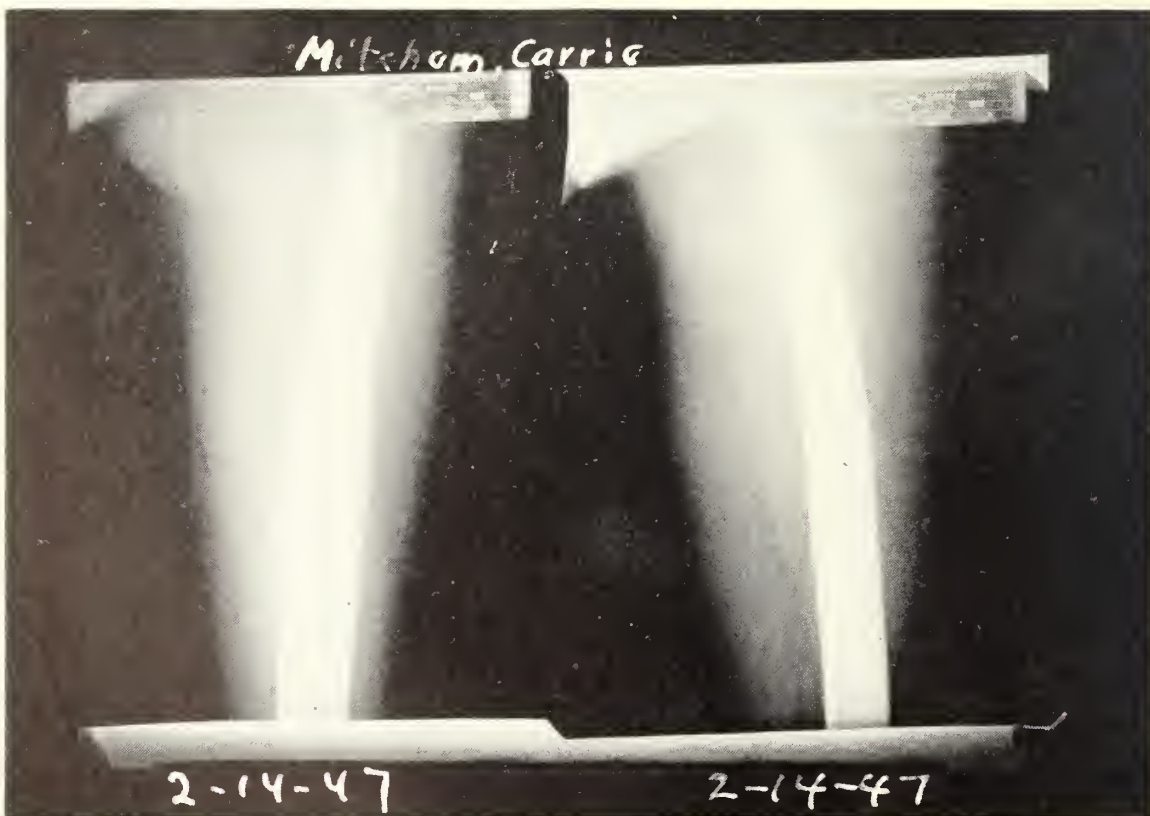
Case 3. Roentgenograms, February 14, 1947. Nonoperative treatment of acute hematogenous osteomyelitis: Preliminary report. John J. Killefer, M.D., and Robert C. Robertson, M.D.
